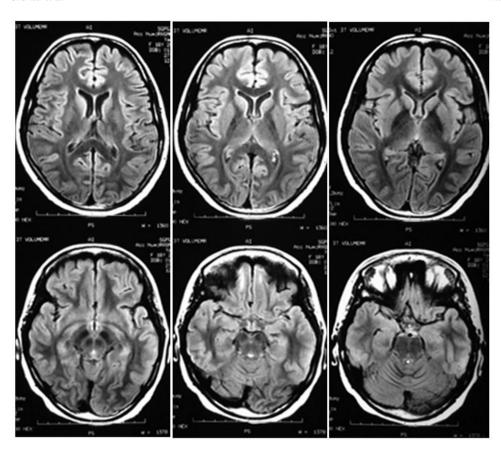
Magnetic resonance imaging (MRI) of brain showing diffuse mild cerebral atrophy.
